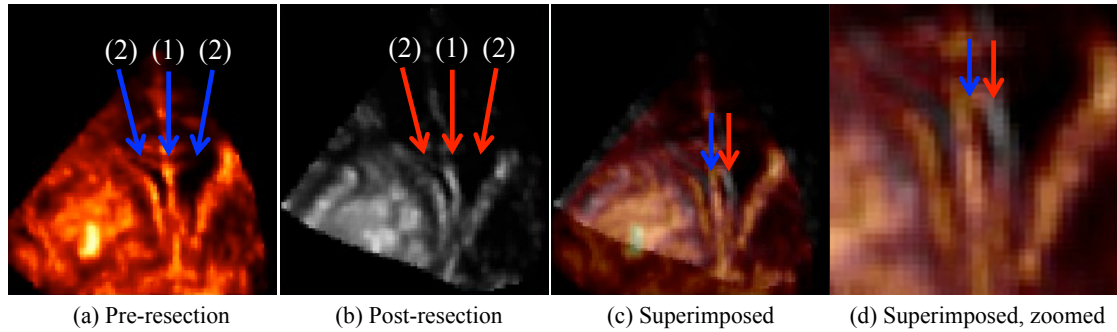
Pre- and post-resection ultrasound images. The misalignment in the superimposed images in (c) and (d) is mainly caused by the brain shift. Structures (1) and (2) are respectively the septum and ventricles. The tumor and the resection cavity are not present in these ultrasound slices.
